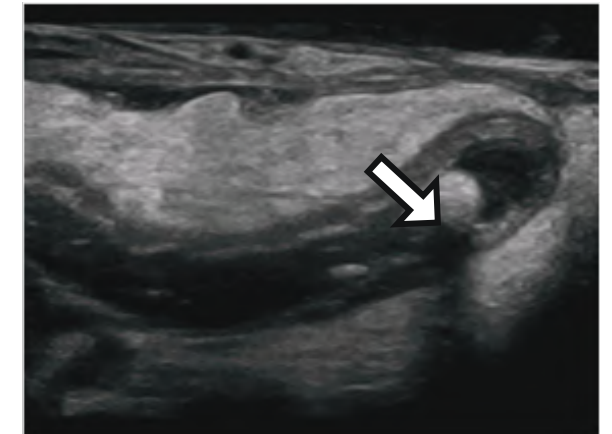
Appendicolith in Ultrasonogram as bright echogenic focus.
